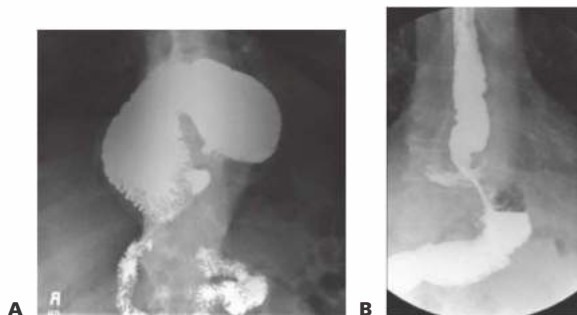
• A,B. Esophagram. A. Radiography demonstrating a large PEH with herniation of nearly the entire gastric lumen into the posterior mediastinum with mesoaxial volvulus. B. Slipped Nissen fundoplication with an intact wrap proximal to the diaphragm.
